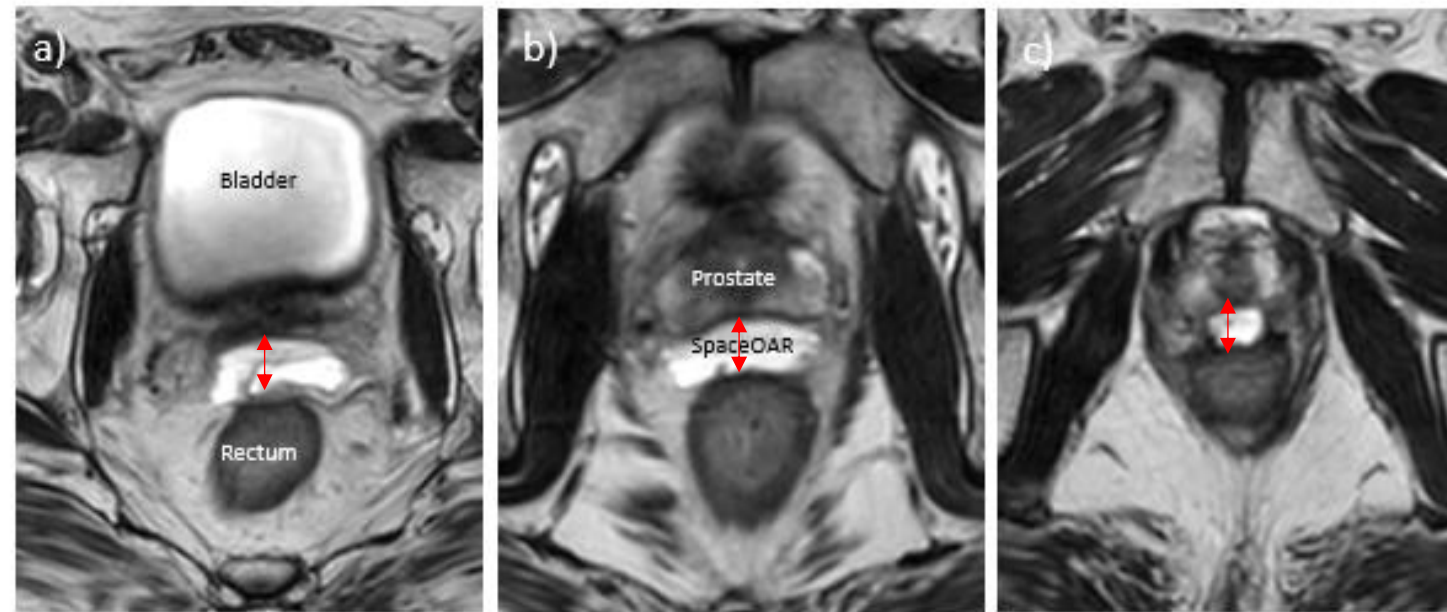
Transverse view of the T2 magnetic resonance image (T2-MRI). a) +1.5 cm from the center of the prostate, b) Center of the prostate, c) -1.5 cm from the center of the prostate.
